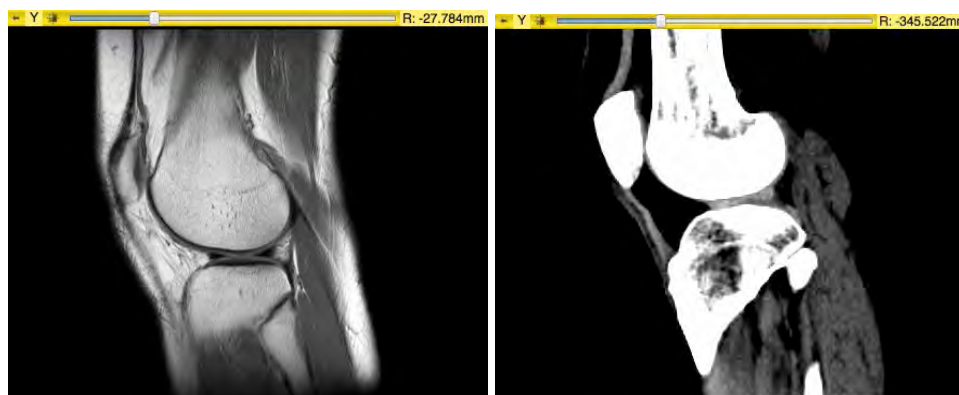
Comparison between MRI (left) and CT-scan (right).
